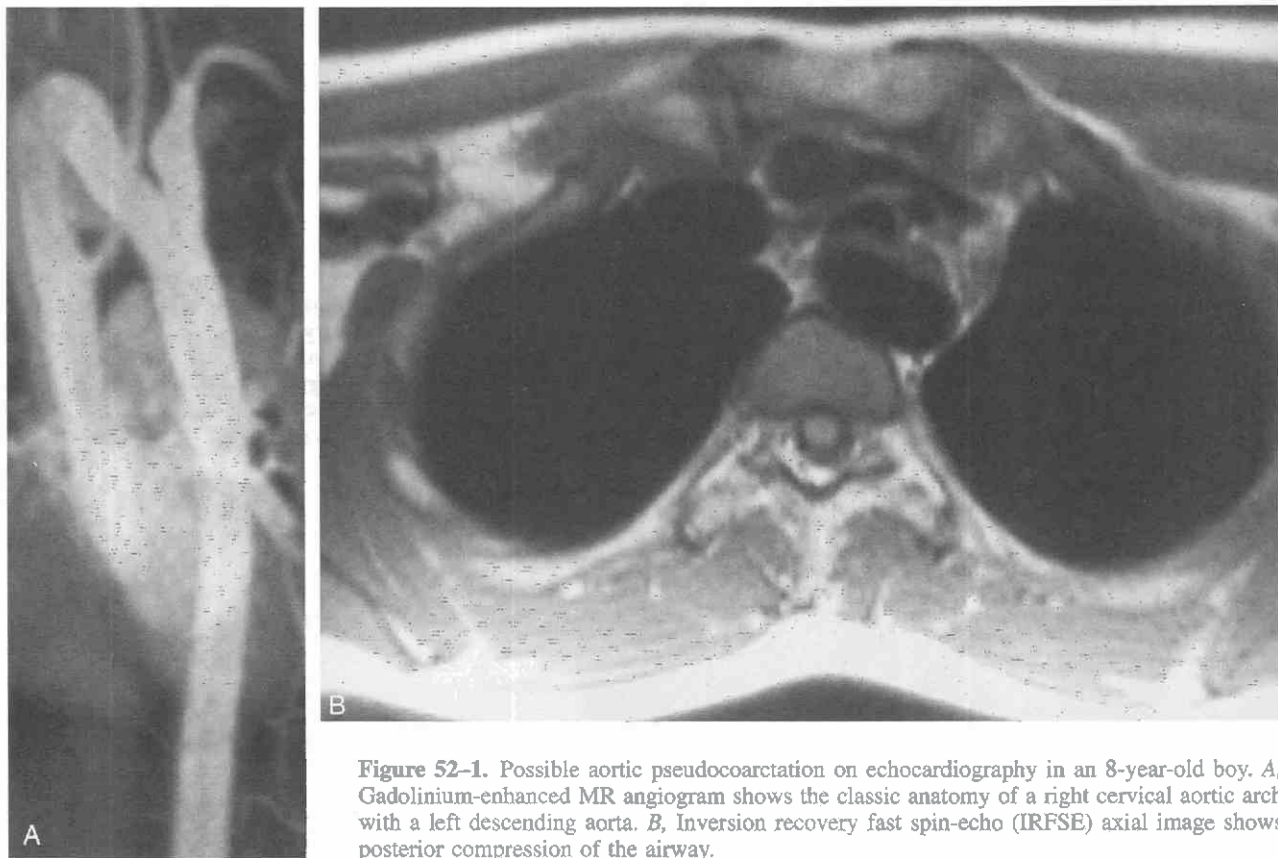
Possible aortic pseudocoarctation on echocardiography in an 8-year-old boy. *A*, Gadolinium-enhanced MR angiogram shows the classic anatomy of a right cervical aortic arch with a left descending aorta. *B*, Inversion recovery fast spin-echo (IRFSE) axial image shows posterior compression of the airway.
